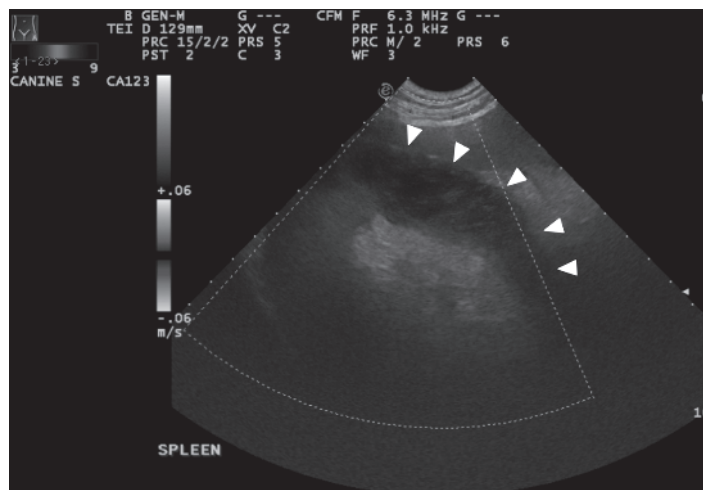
Partial splenic torsion. Ultrasound image of a 4-year-old Great Dane with evidence of a hypoechoic and roughly triangular region (outlined by arrowheads) in the distal tail of the spleen consistent with a partial splenic torsion (courtesy Dr. Robert O'Brien, DVM, DACVS).
